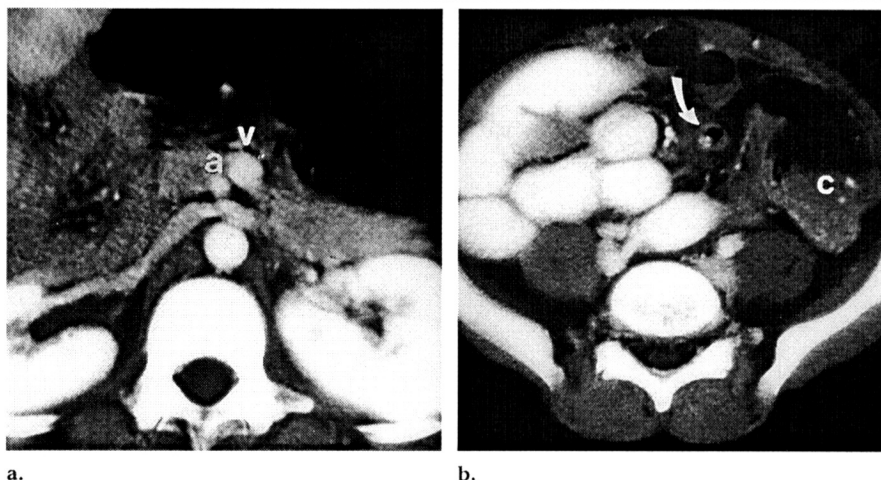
Midgut malrotation and appendicitis. (a) Transverse CT scan through the upper part of the abdomen after the administration of intravenous and oral contrast material in a 10-year-old boy with acute abdominal pain demonstrates reversal of the mesenteric artery (a) and vein (v), which is indicative of midgut malrotation. (b) Transverse CT scan through the lower part of the abdomen in the same child demonstrates an enlarged appendix (arrow) of 9-mm maximal diameter in the left lower quadrant, with periappendiceal inflammatory changes. Note the location of the cecum (C) in the left lower quadrant.
